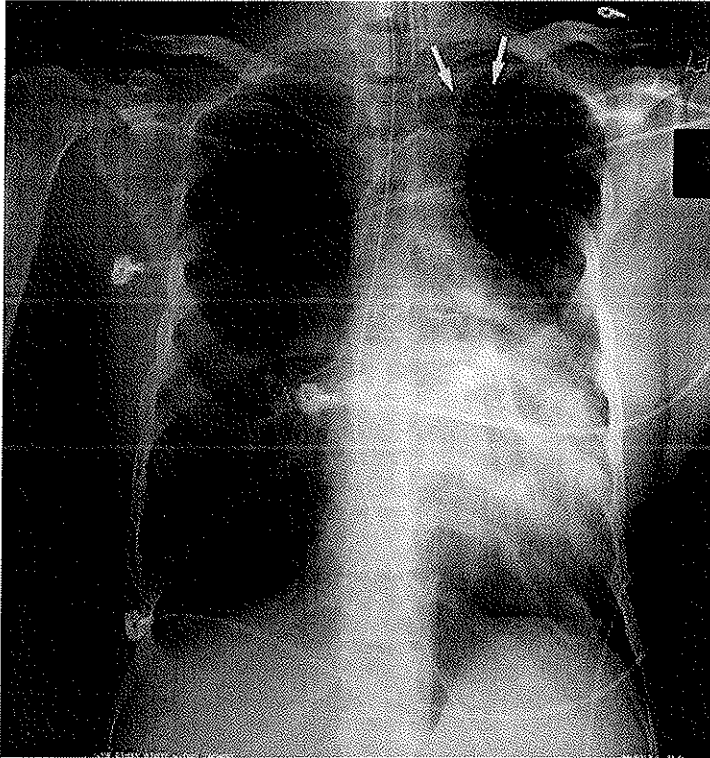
Chest radiograph taken 2 days after left subclavian central venous catheter insertion. A small apical pneumothorax is present (arrows).
